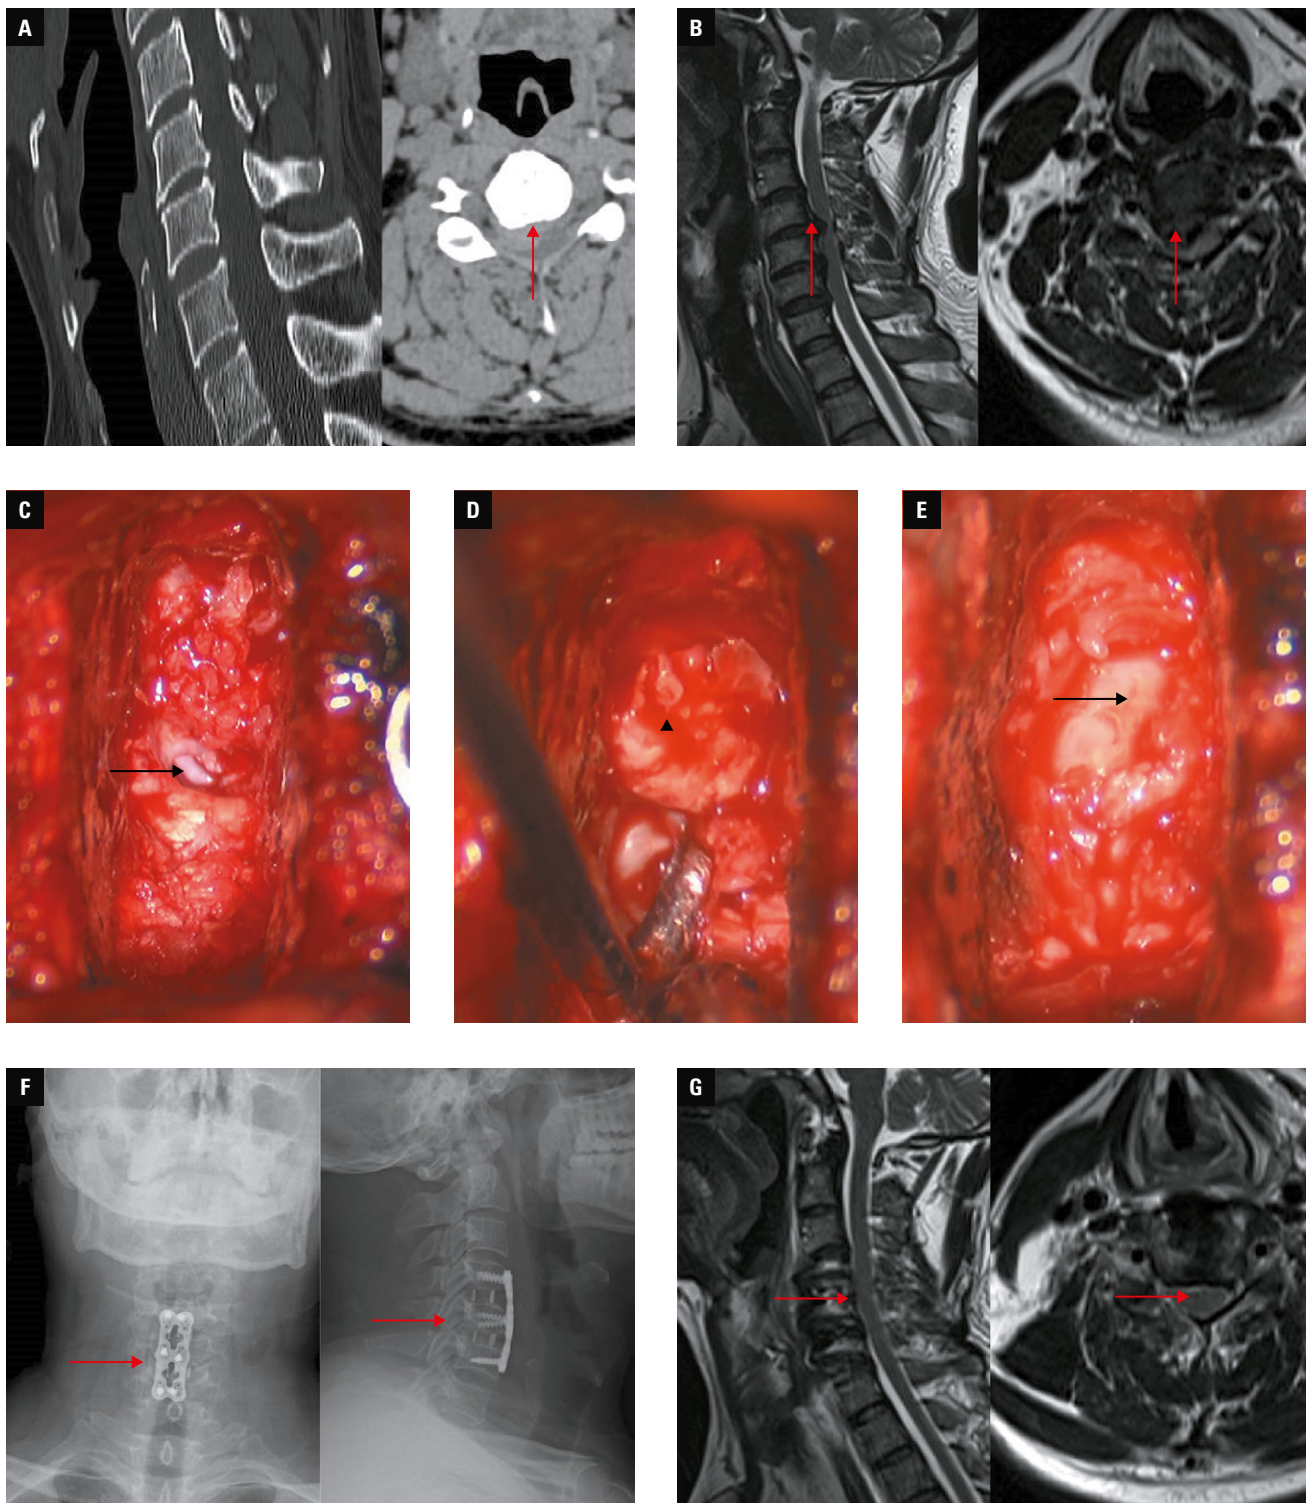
Case 2. A 61-year-old man with weakness and numbness in upper and lower extremities that had persisted for 48 months; A – preoperative sagittal computed tomography showing no ossification of the posterior longitudinal ligament, and a coronal view showing the herniated disc at the C4/C5 level (arrow); B – preoperative magnetic resonance imaging showing giant disc herniation in the C4/C5 intervertebral space (arrows); C – natural rupture formed by the herniated nucleus pulposus tissue in the intervertebral space (arrow); D – protruding free nucleus pulposus tissue (arrowhead); E – spinal cord distension and filling after removing the herniated cervical disc to relieve compression (arrow); F – postoperative frontal and lateral radiographs showing the implanted cage-plate system (arrows); G – postoperative MRI with spinal cord re-expansion after decompressive discectomy (arrows)
